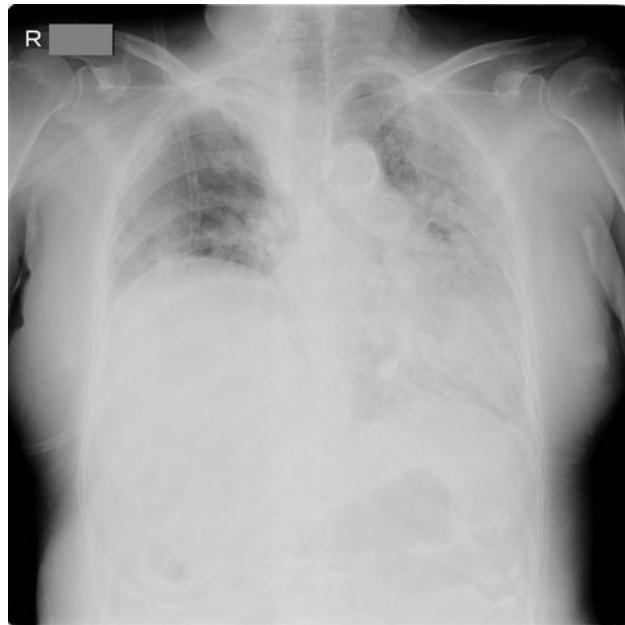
Chest X-ray on 4th postoperative day (POD) after second operation shows diffuse infiltrates in the bilateral lung
